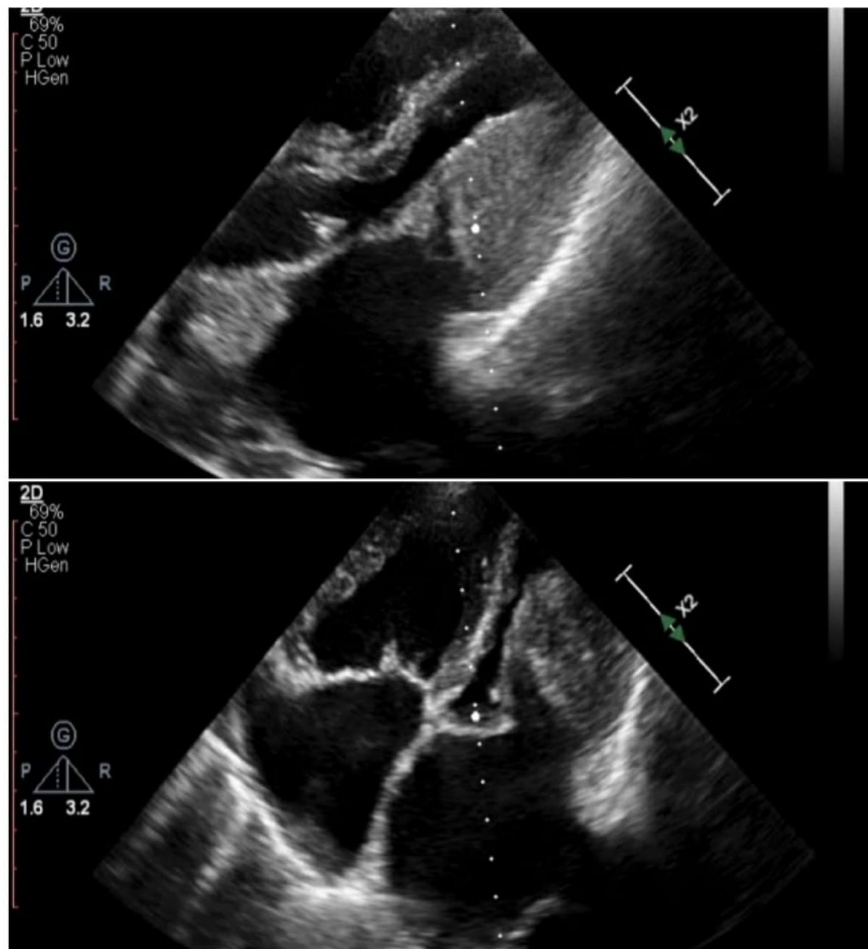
(1 a.) transthoracic echocardiography modified apical 5-chamber view showing large homogenous mass of same echodensity as of surrounding endocardium attached to lateral wall of left ventricle, filling the lumen of left ventricle. (1 b.) apical 4 chamber view showing homogenous mass attached to lateral wall of left ventricle causing mitral inflow obstruction
